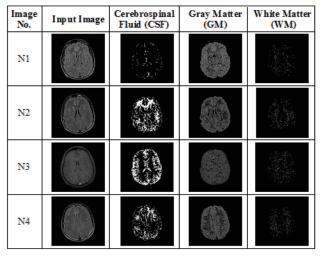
Segmented normal tissues (CSF, GM, WM) and pathological tissues(tumor) of MRI brain images without tumor
